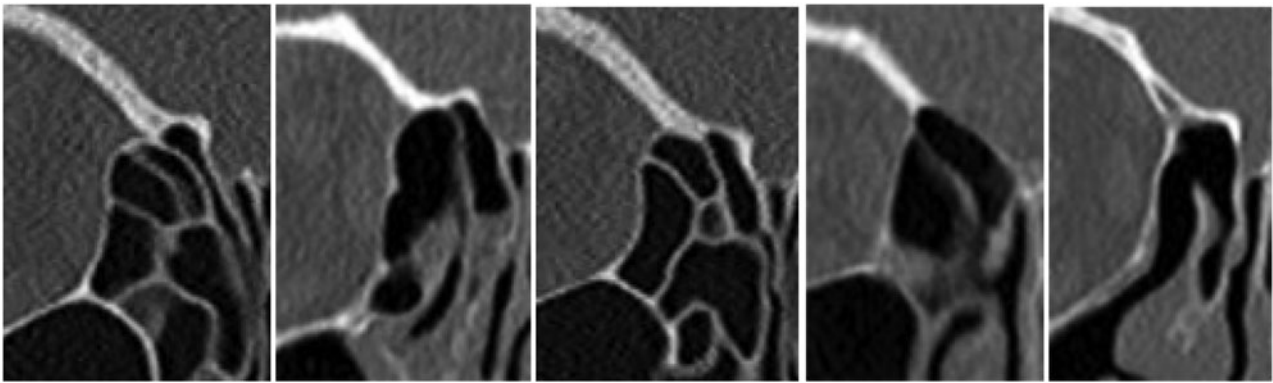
Examples of cropped coronal computed tomography images for which the algorithm misclassified the artery as lying in a 'mesentery' that also demonstrated a thickened supraorbital ridge.
